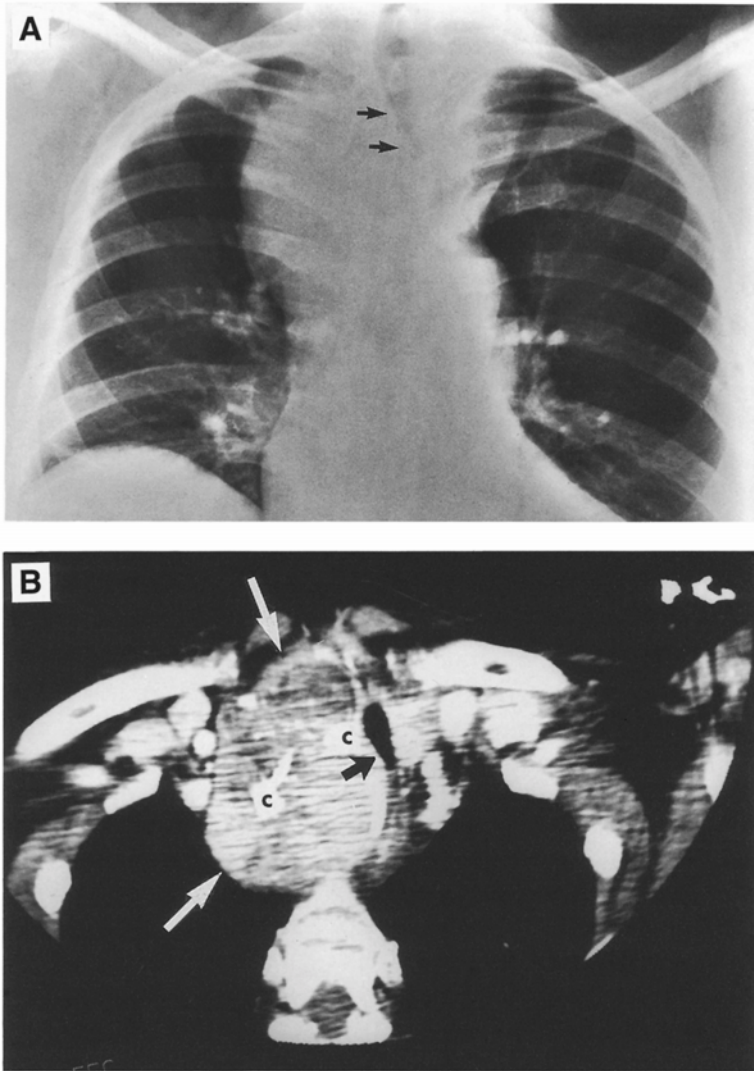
Multinodular goiter in a 62-yr-old patient with symptoms of stridor. (A) Chest radiograph showing a large substernal mass with tracheal deviation and narrowing. (B) Computerized tomography at the level of the thoracic inlet, demonstrating the goiter (white arrows), tracheal narrowing (black arrows), and calcium deposits (c) within the goiter.
